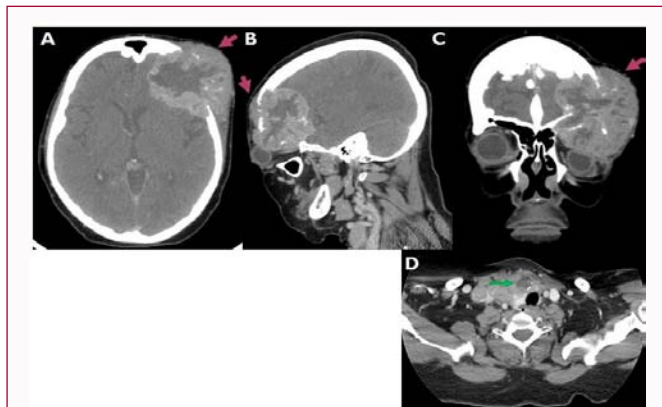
The A) Axial B) Sagittal and C) Coronal images of the CT of the brain revealed intraosseous destructive lesion within the left frontal bone with intracranial and intraorbital extension. D) The visualized part of the thyroid gland and lower neck demonstrates an incidental hypodense lesion at the level of the right thyroid lobe.
